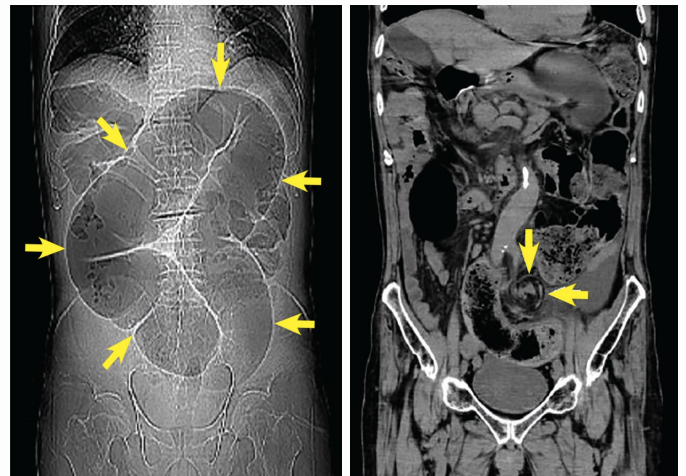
CT abdomen and pelvis showing distended sigmoid loop with inverted U-shape (arrows), known as coffee bean sign (left image). CT coronal view of whirl sign, representing twisted bowel and mesentery (arrows) (right image). From "Sigmoid volvulus: Coffee bean sign, whirl sign," by Yusaku Kajihara, MD, FACP, 2020, *Cleveland Clinic Journal of Medicine*, 87 (2) 81-82; DOI: <https://doi.org/10.3949/ccjm.87a.19064>.
